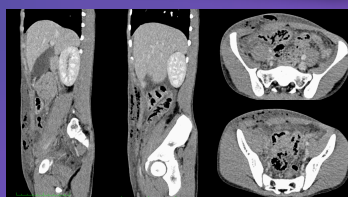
CT abdomen showing 1.5x0.6 cm abdominal wall defect with intrabdominal content and vesicula herniation, likely omentum and colonic perforation by presence of pneumoperitoneum.
